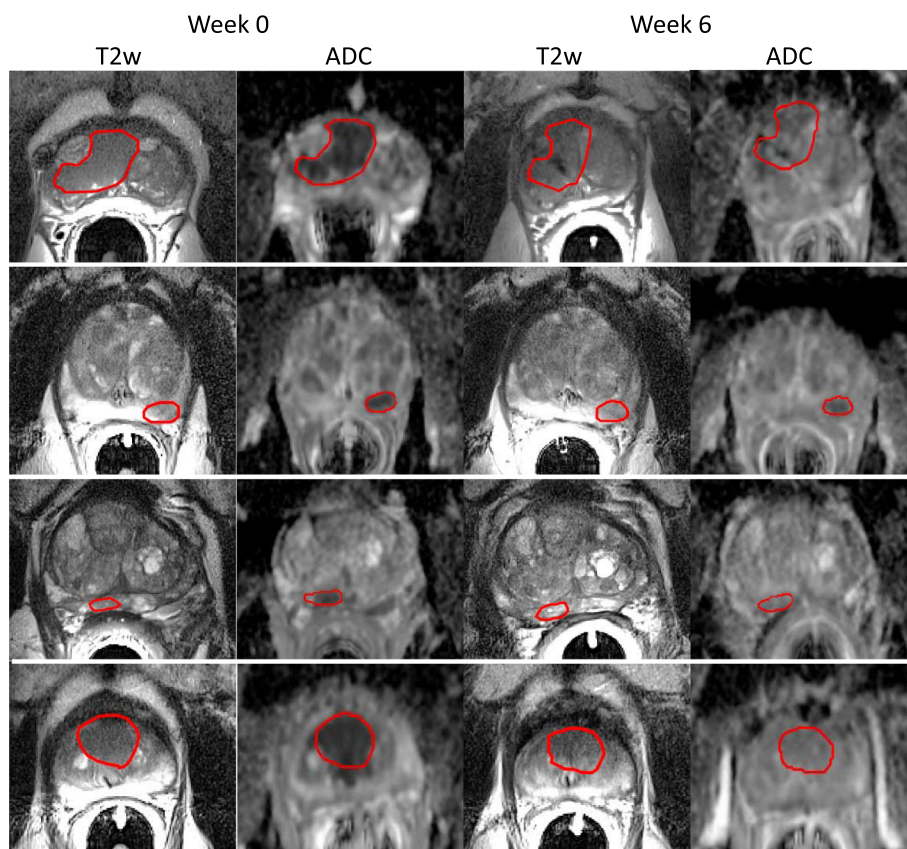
T2-weighted images and ADC maps from four patients at baseline (left) and week six (right). These images emphasize the need for deformable registration, because of loss of prostate-to-tumor contrast post-EBRT and shifts in prostate orientation between time-points. Routine distortion in diffusion-weighted images compared to T2-weighted images motivates additional correction of GTVs applied to ADC maps.
